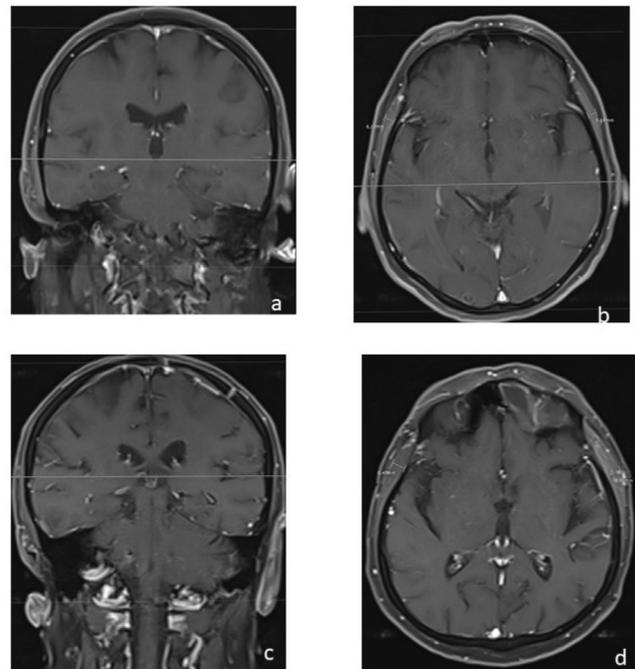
Representative TMT assessment on contrast-enhanced cranial T1-weighted MR images. Coronal (a), axial (b) images of a female patient (mean TMT =5.68 mm) and coronal (c) and axial (d) views of a male patient (mean TMT =8.56 mm) TMT was measured at the level of the orbital roof perpendicularly to the long axis of the temporal muscle on an axial plane, which was oriented parallel to the anterior-posterior commissure line
